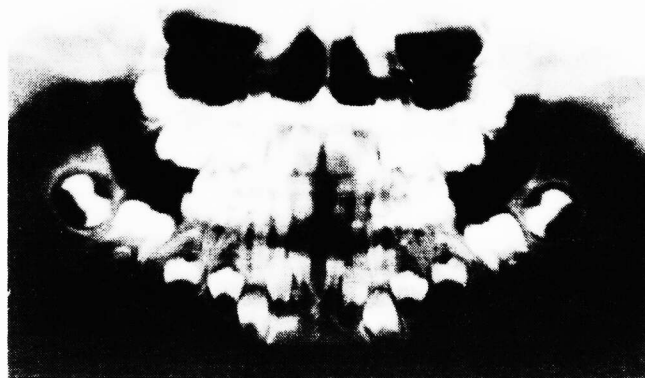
Panoramic X-ray of the same child (fig. 3), comparing the presence of diastema (superior and inferior). Observe the deciduous dentition.
